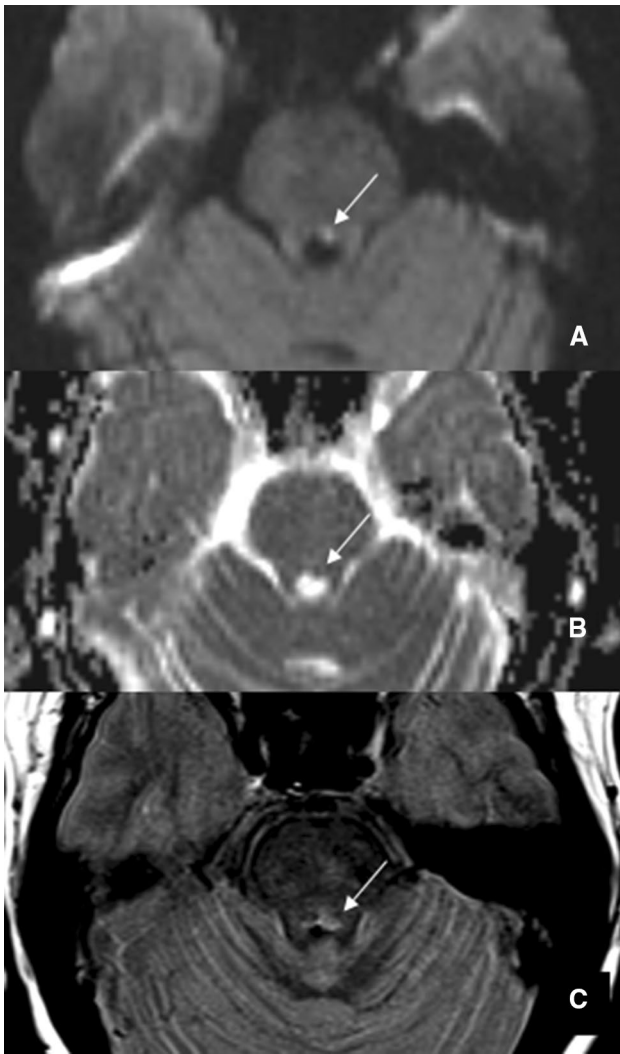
Brain MRI showing on diffusion weighted (A), ADC map (B) and PD weighted (C) the presence of left-sided acute facial colliculus infarction
